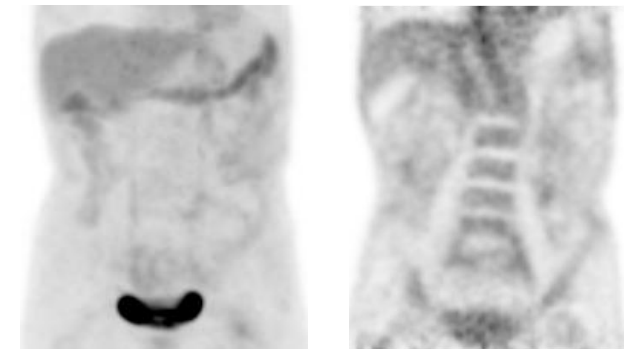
⁶⁸Ga-citrate imaging was negative in one EATL (Type II) patient (right) while ¹⁸F-FDG imaging was also negative (left).
